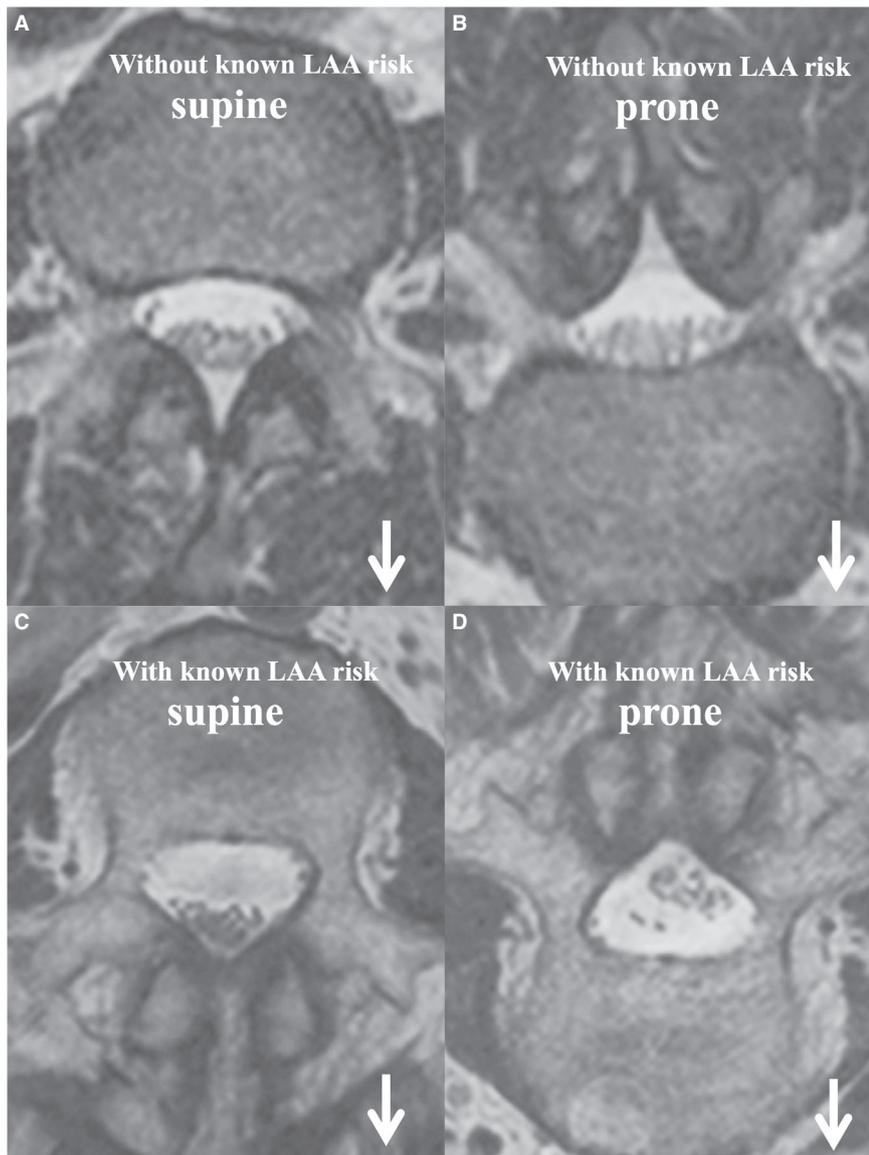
Demonstration of axial T2-weighted magnetic resonance images of the L4 middle level in the supine and prone positions in patients with or without known risk factors for lumbar adhesive arachnoiditis. The upper panels (A and B) are images from a single patient without known risk factors for the condition. The lower panels (C and D) depict the results for a single patient with a known risk factor (ie, lumbar spinal surgery) for the condition. Arrows indicate the gravitational force direction. MRI evaluations with postural changes can help visualize the intrathecal mobility of the lumbar nerve roots and cauda equina. LAA, lumbar adhesive arachnoiditis.
